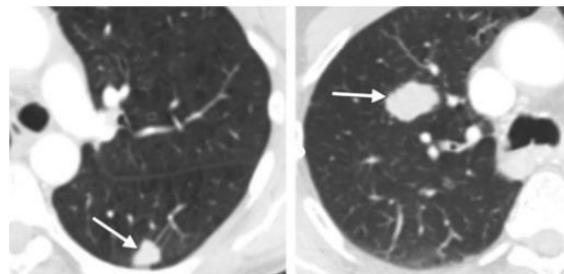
Stage T1 tumor's (Chest CT scan)
